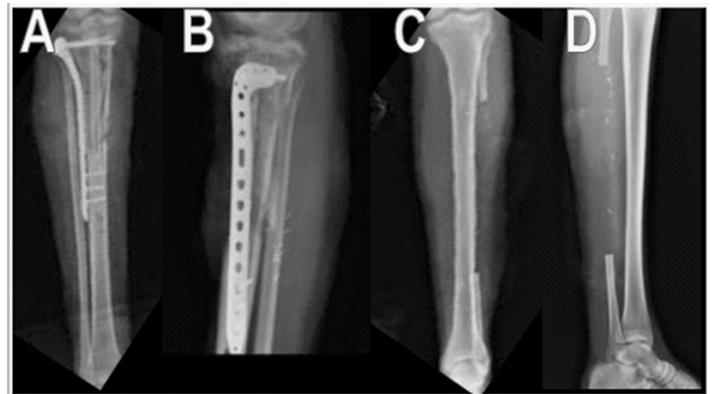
Radiographs of the right pelvic limb; A and B- AP radiographs of the right foot with postoperative changes due to pelvic limb reconstruction using the microvascular free peroneal flap with the use of osteosynthesis material (oss with anatomical plate on the tibial plateau); C and D- AP and lateral radiographs of the left leg with postoperative changes due to the harvest of the graft for the microvascular free peroneal flap, only the proximal and distal epiphyses of the fibula are observed.
